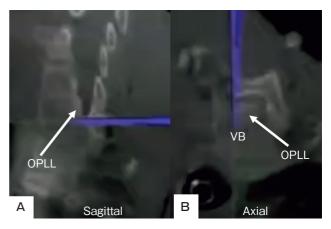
Intraoperative CT. A, Sagittal reconstruction CT; B, Axial CT.
